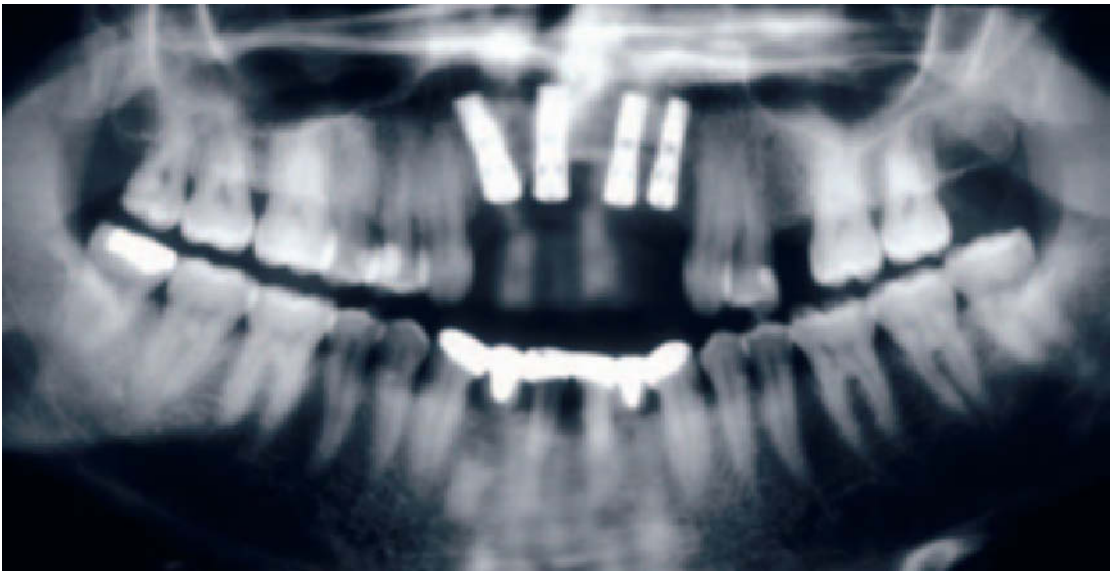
Panoramic radiograph of implants in place.
